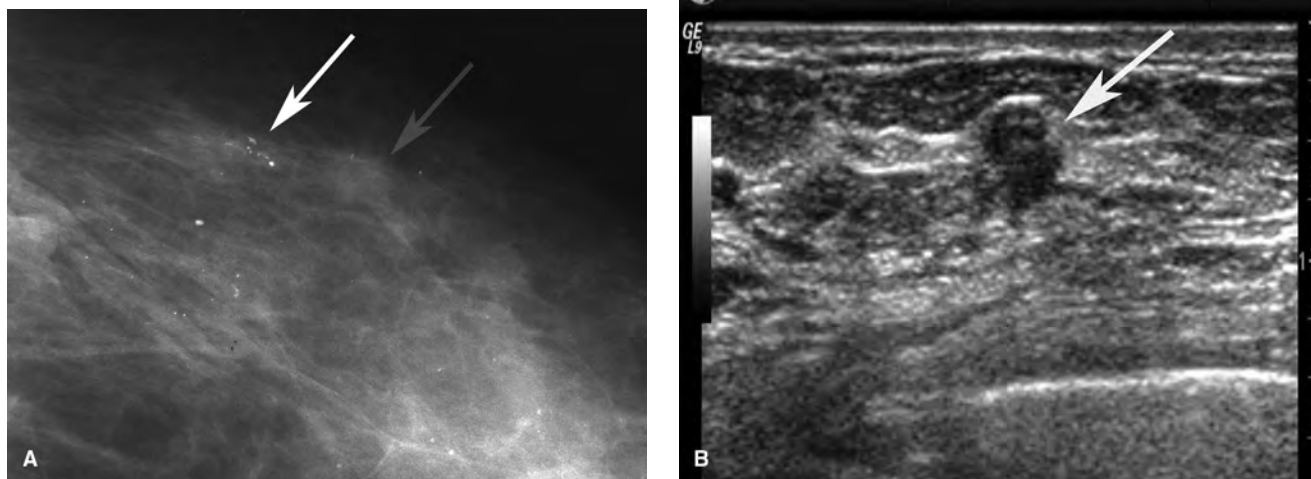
Ultrasound-guided biopsy of an invasive ductal carcinoma. (A) Mammogram demonstrates calcifications (*white arrow*) and adjacent soft tissue mass (*grey arrow*). (B) Targeted ultrasound identified a sonographic correlate to the mammographic density (*arrow*). Ultrasound-guided biopsy yielded invasive ductal carcinoma with DCIS. Calcifications were associated with the DCIS.
